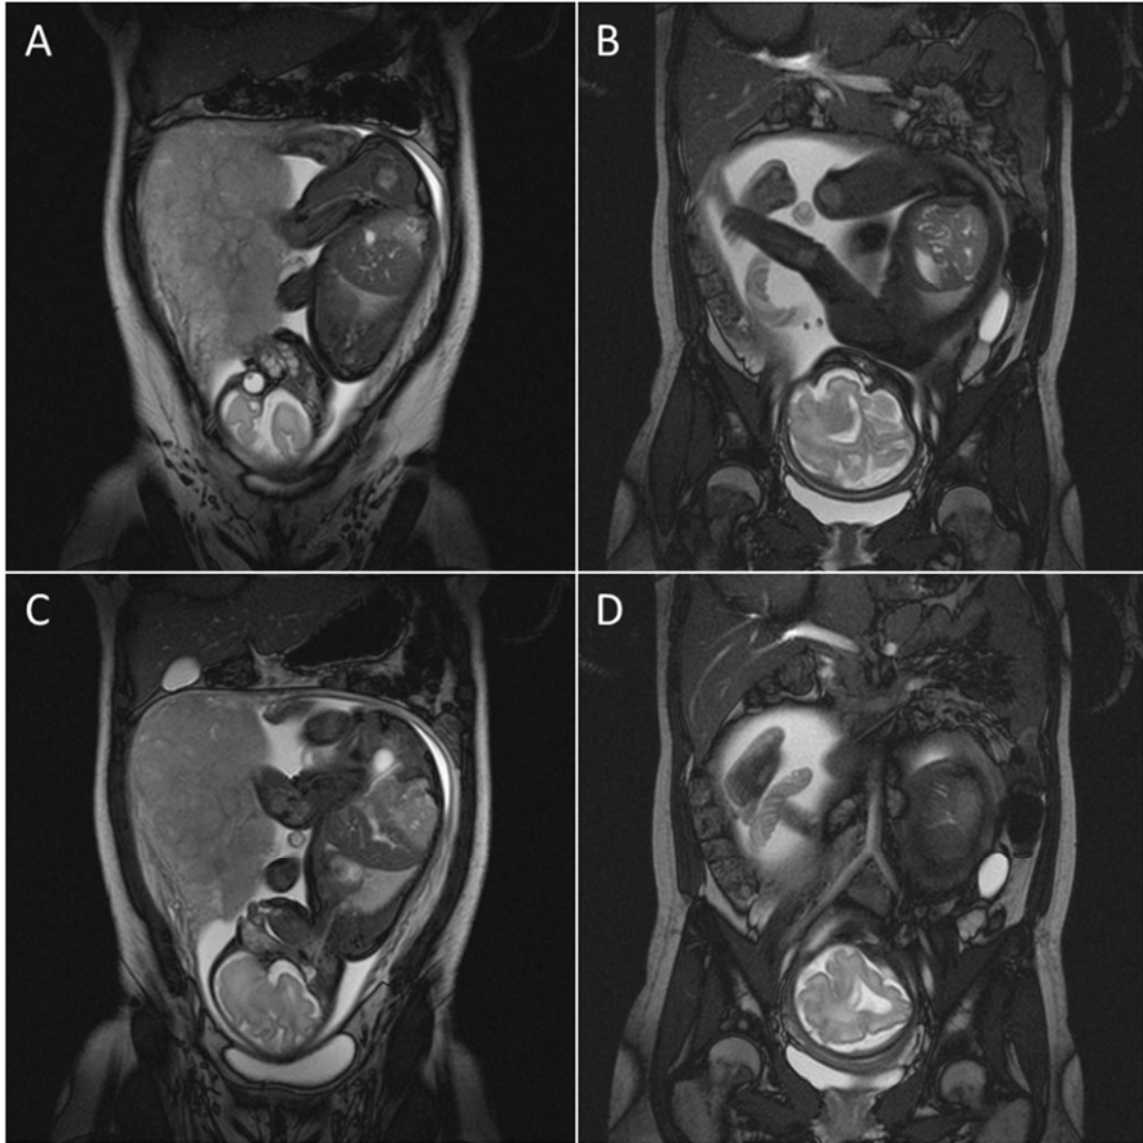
Frontal Plane MRI Scans of Human Pregnancy
